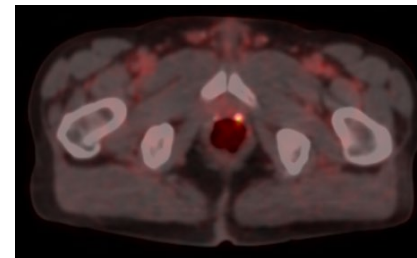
PSMA PET-CT image showing avid disease recurrence in the prostate resection bed, encompassable in a prostate bed radiotherapy field
